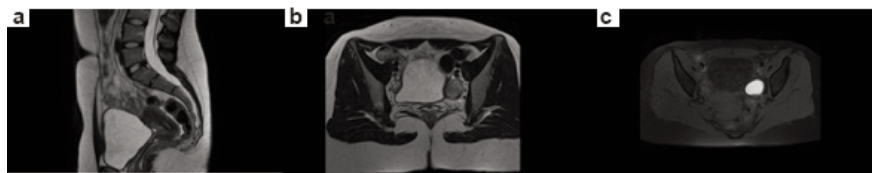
MRI of the pelvis did not show extensive infiltration of the mass. (a) Sagittal T2 – normal female pelvis. (b) Axial T2 – normal female pelvis. (c) Axial T1 – normal female pelvis.
